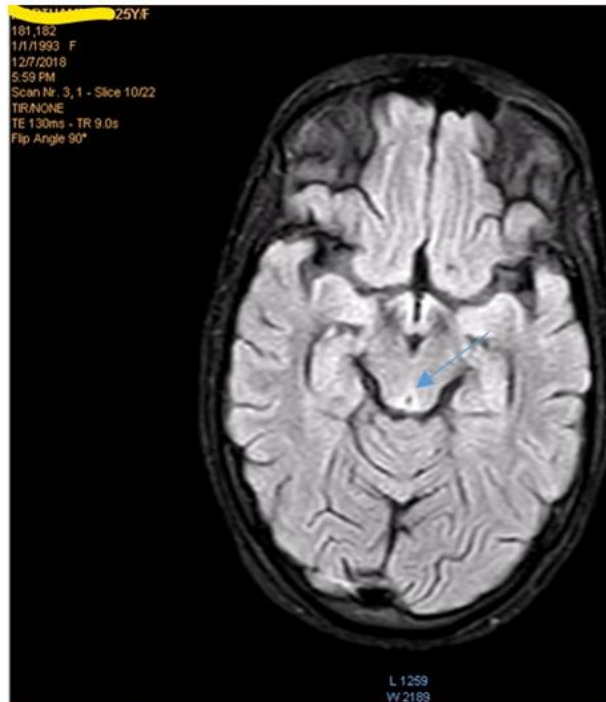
FLAIR-MRI Brain showing hyperintensities in periaqueductal gray matter
